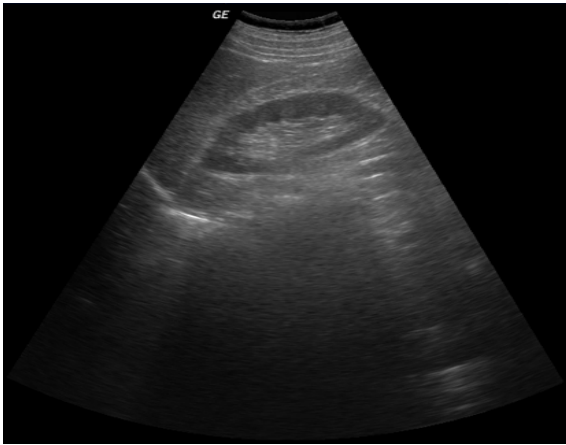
A - Real Ultrasound Machine
